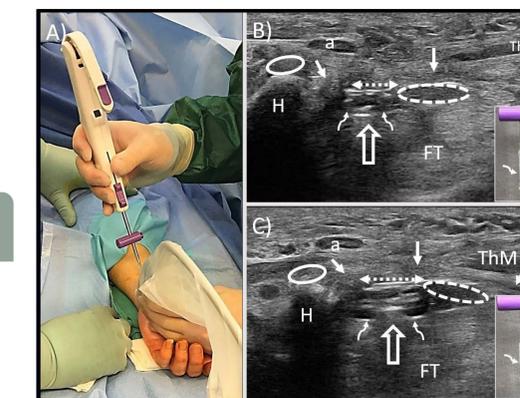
A. Placement of device through incision, then guided into tunnel under direct sonographic visualization. B. Device sitting in TSZ. C. Device with balloons expanded in TSZ. Dotted ellipse = median nerve. Curved arrows = balloons of device. Arrows = TCL. Open Arrow = device center, FT= flexor tendons, ThM = thenar muscle, H = hamate, a = ulnar artery, closed oval = ulnar nerve
